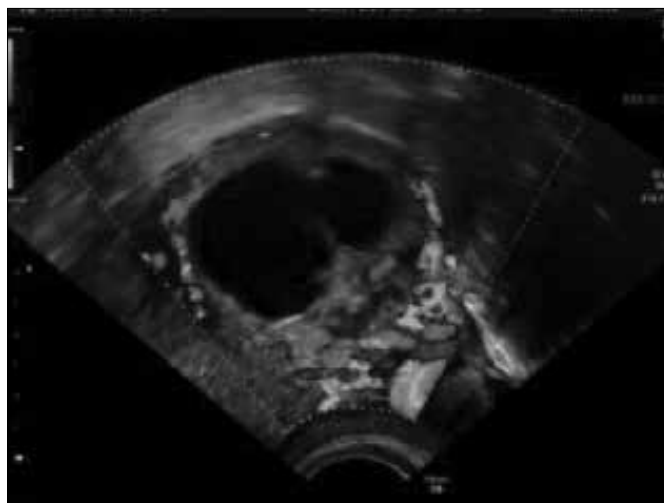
Colour doppler sonography of ectopic pregnancy
